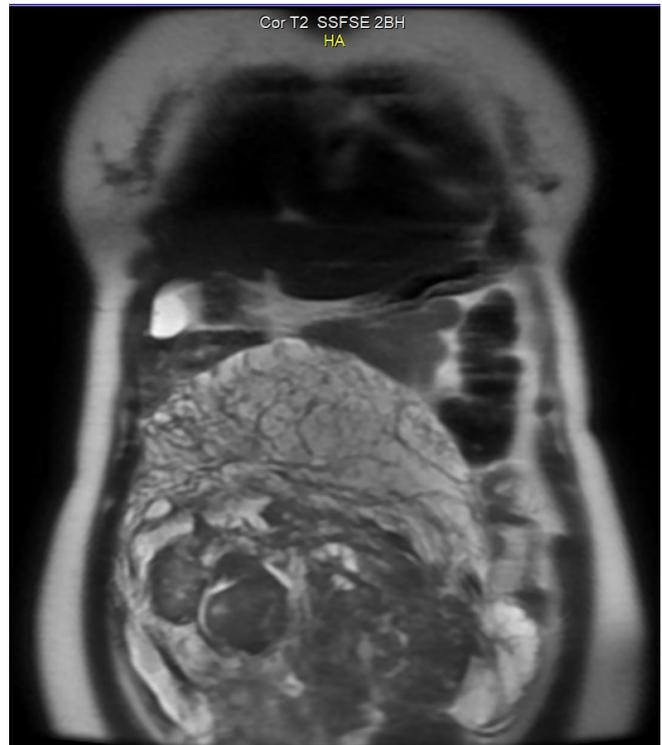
MRI image of giant pelvic mass filling whole abdominopelvic cavity with heterogenous and semisolid appearance.
